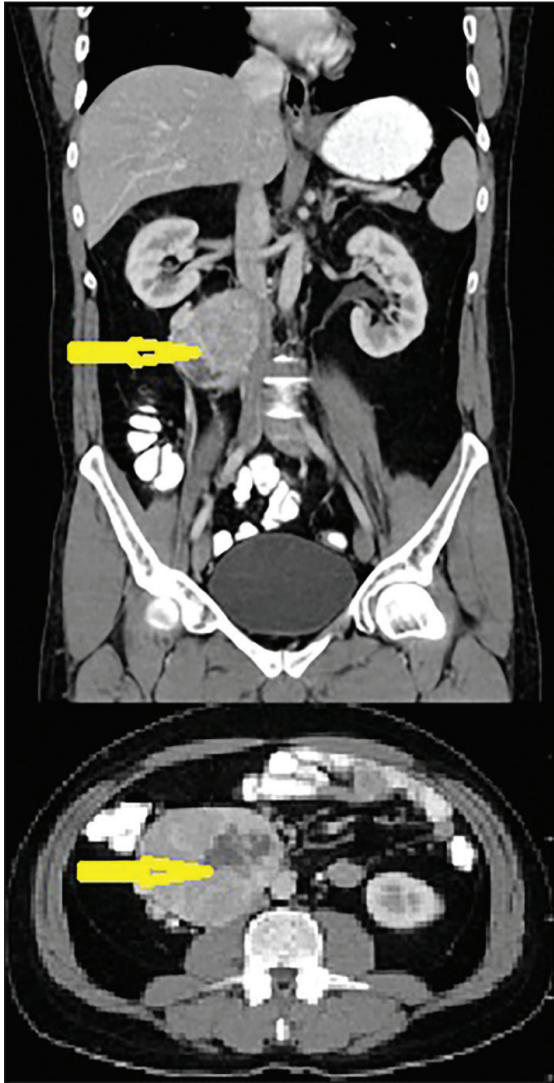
CT image of a 92×87 mm², irregularly shaped, contrast-enhanced mass detected in the precaval and aortocaval areas at an infrarenal level contiguous with the duodenum.
